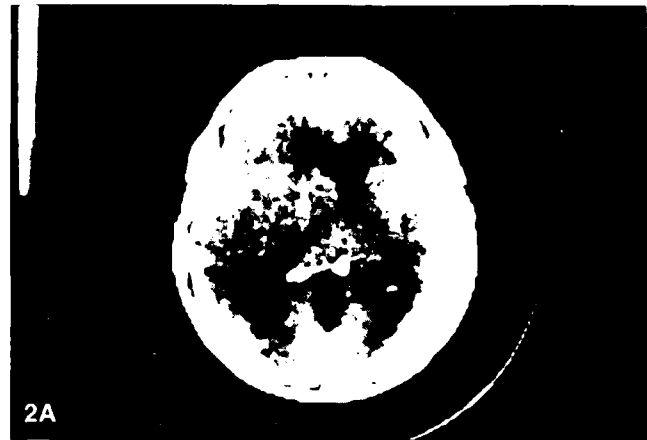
CT brain scan, non-contrast-enhanced, 45-year-old woman. (A) Initial scan, 1½ hours after injury. Patient was stuporous, agitated, no focal signs. (B) Scan 14 hours after initial scan. Patient stuporous, agitated, mild left hemiparesis, slightly dilated right pupil. A large hematoma has formed in the right middle fossa. Prompt removal of the clot and intensive care resulted in complete recovery.
